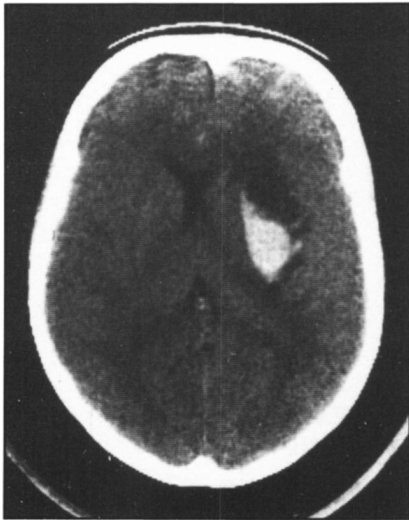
This figure of the initial cranial CT scan done within 24 hours of the carotid endarterectomy shows a hemorrhage in the basal ganglion and internal capsule region.
